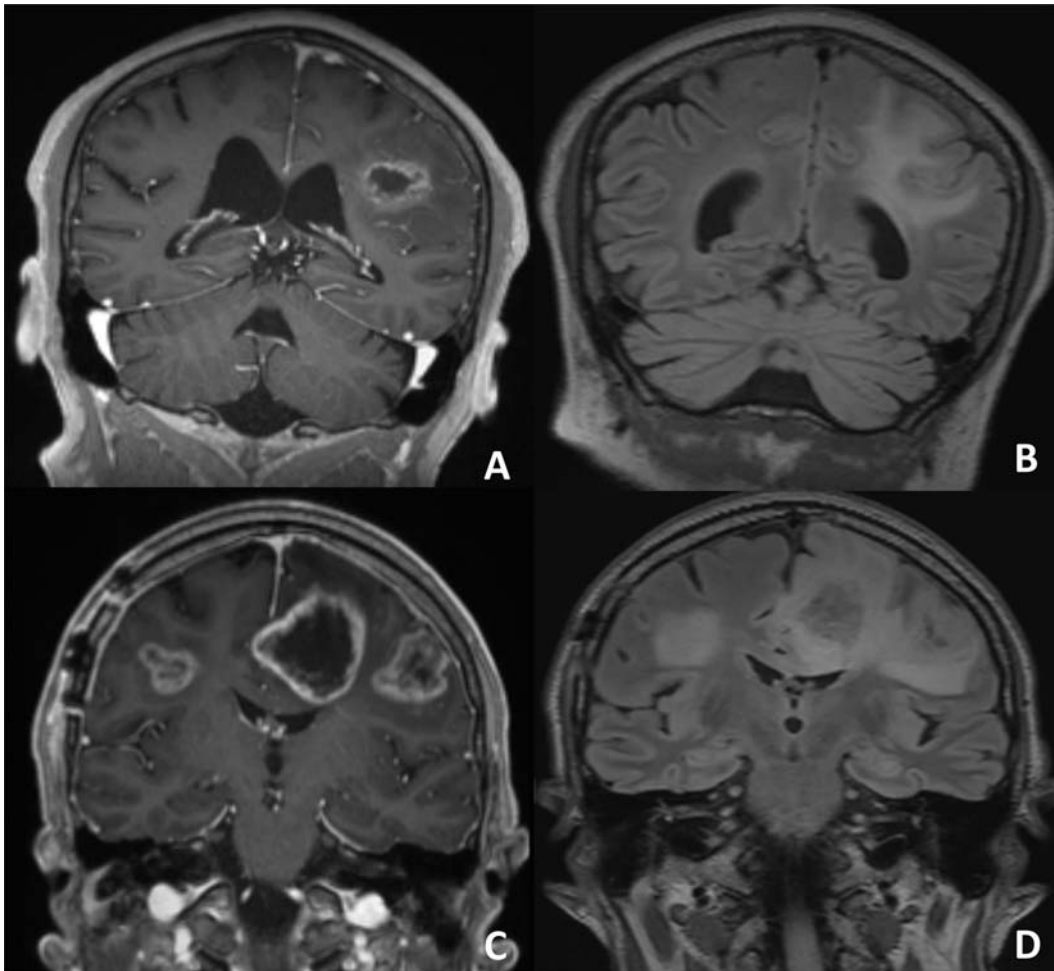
Panel A and B Postcontrast T1-weighted and FLAIR MRI images showing left frontal lobe IDH wildtype glioblastoma; Panel C and D Post-contrast T1-weighted and FLAIR MRI images of a different patient with multifocal glioblastoma.
